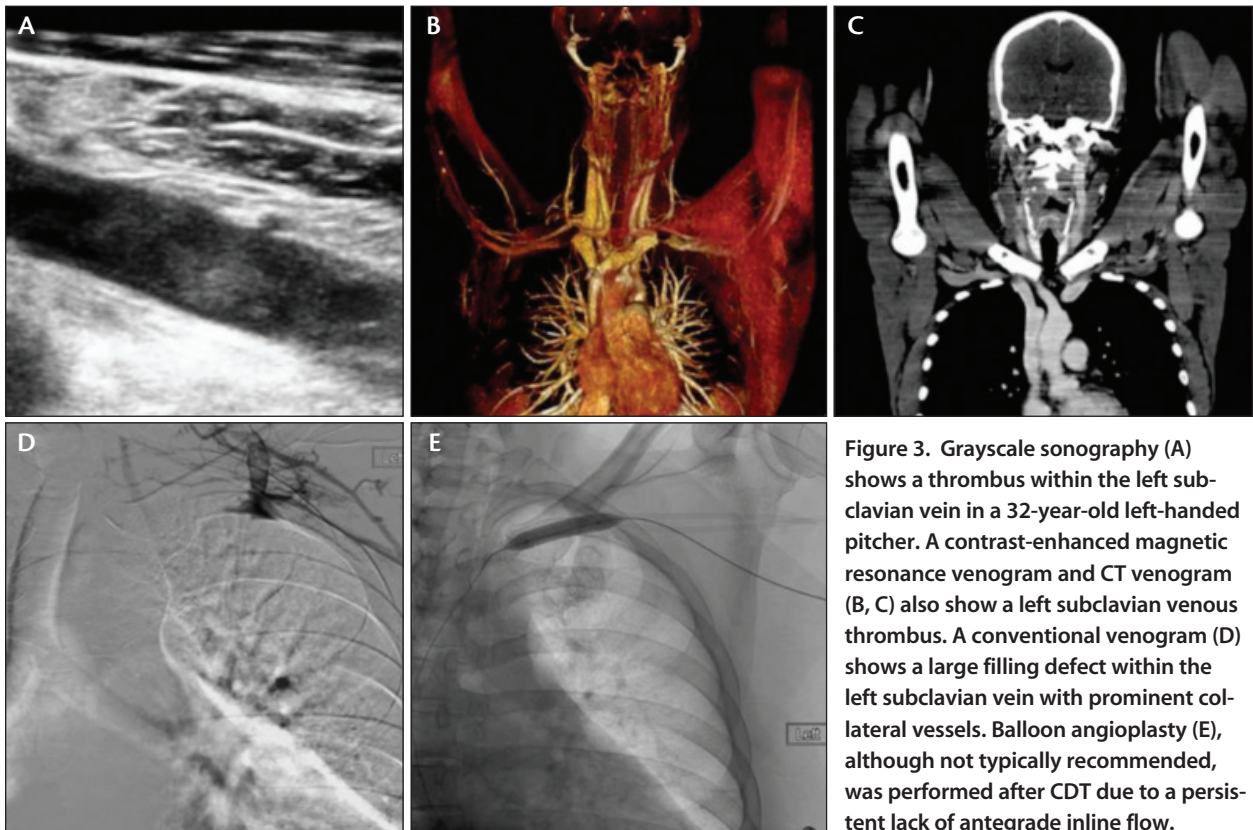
Grayscale sonography (A) shows a thrombus within the left subclavian vein in a 32-year-old left-handed pitcher. A contrast-enhanced magnetic resonance venogram and CT venogram (B, C) also show a left subclavian venous thrombus. A conventional venogram (D) shows a large filling defect within the left subclavian vein with prominent collateral vessels. Balloon angioplasty (E), although not typically recommended, was performed after CDT due to a persistent lack of antegrade inline flow.
